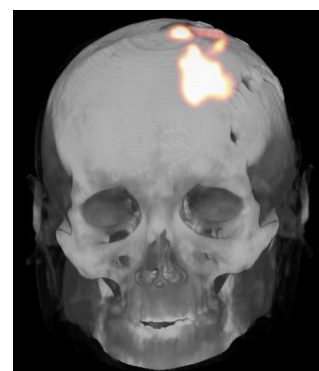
^{68}Ga -DOTATOC PET/CT image of a patient with recurrent glioblastoma after co-injection of 10 MBq ^{68}Ga -[Thi⁸,Met(O₂)¹¹]-substance P and 1.7 GBq ^{213}Bi -[Thi⁸,Met(O₂)¹¹]-substance P. The image taken at 1 hour post injection shows high retention of the radiolabelled compound in the tumor area, with some residual activity remaining in the catheter system.
